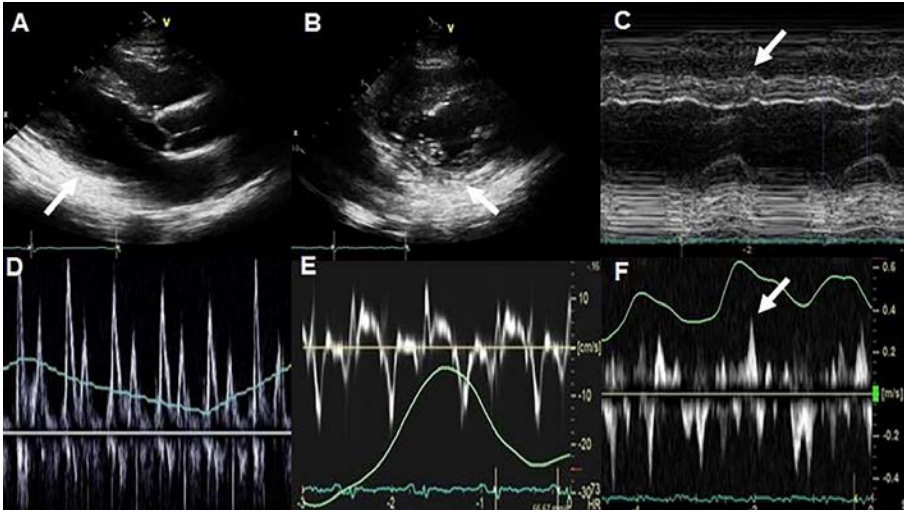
Echocardiographic study of a patient with constrictive pericarditis. 2-D echocardiography showing pericardial thickening and calcification: (A) parasternal long axis view (arrow); (B) parasternal short axis view (arrow); (C) M mode echocardiography shows interventricular dependence (arrow); (D) pulsed wave Doppler recording of mitral inflow velocity showing respiratory variation; (E) septal e' velocity of tissue Doppler imaging is about 14 cm/s; (F) hepatic vein pulsed wave Doppler shows diastolic flow reversal with expiration (arrow) [14.14–14.17].
